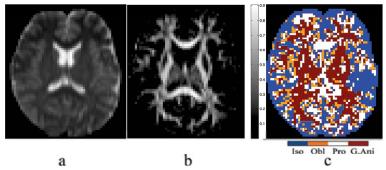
a) T2-weighted image; b) FA and c) Model Selection maps
